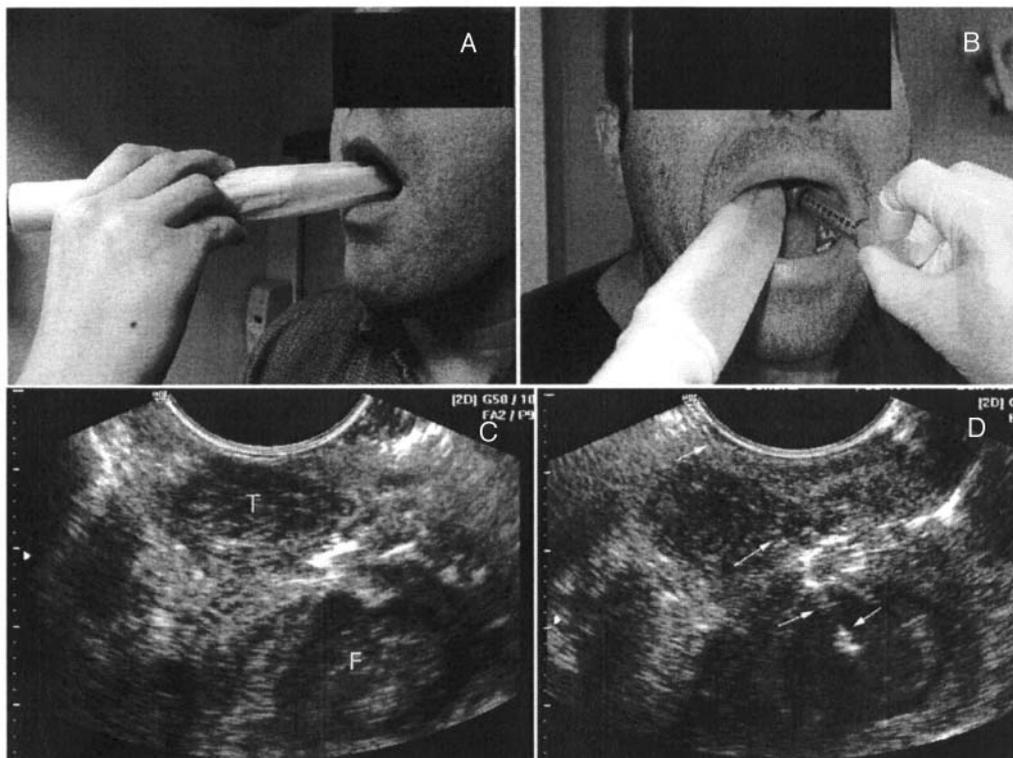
An endocavity transducer is inserted into the mouth to scan the peritonsillar region, A. A syringe with an 18-gauge needle is inserted next to the transducer to allow ultrasound-guided abscess aspiration, B. An abscess is shown on intraoral ultrasound (f: fluid) that is deep to the tonsil (t), C. A needle (arrows) is seen inserting into the abscess for drainage, D.
